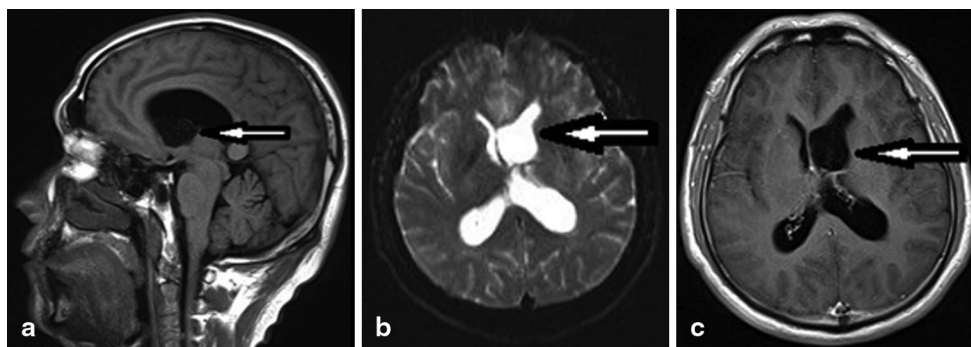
Cystic pilocytic astrocytoma in the lateral ventricle. a Sagittal T1-weighted magnetic resonance (MR) images show the cystic lesion at low signal intensity with clear margins (*arrow*) and an enlarged supratentorial brain ventricle. b Axial T2-weighted MR images show
